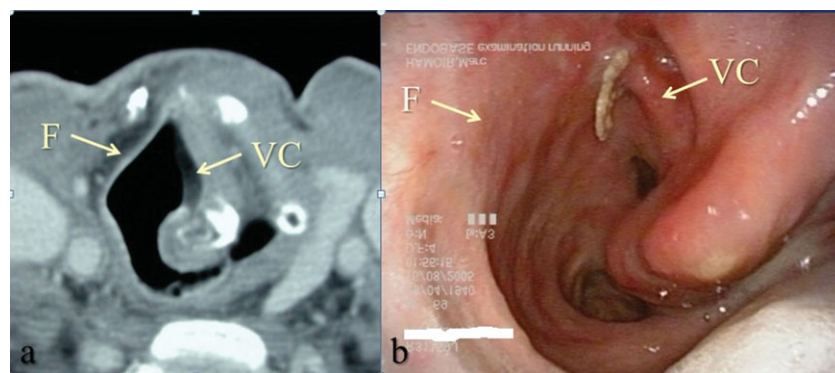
CT scan (A) and endoscopic view (B) after a left vertical hemilaryngopharyngectomy. The reconstruction of the laryngopharynx is performed using a folded radial forearm flap (F) supported in the glottis area by a cartilage graft (a suture is visible). The spared right vocal cord (VC) is well identified. [Color figure can be viewed in the online issue, which is available at wileyonlinelibrary.com.]
